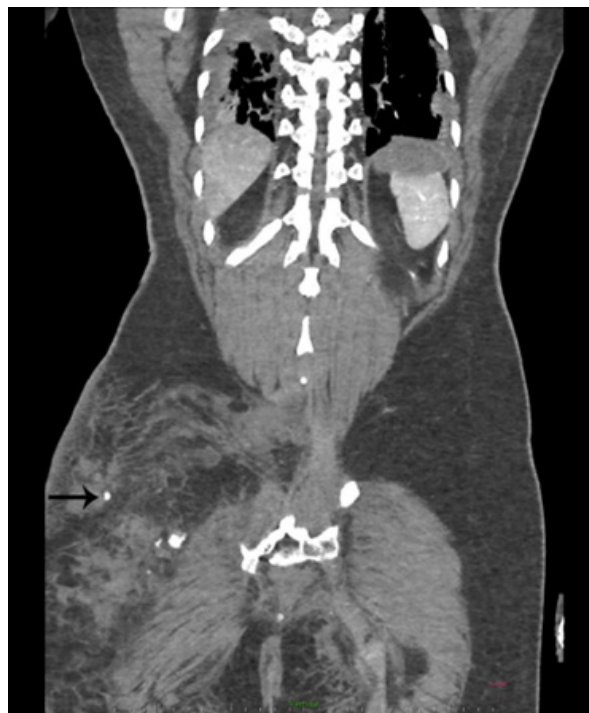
Coronal plane image from the CT abdomen scan obtained during the arterial phase demonstrates active contrast extravasation (black arrow) from an artery with a large surrounding hematoma. The left side of the image shows normal subcutaneous tissue for comparison.
